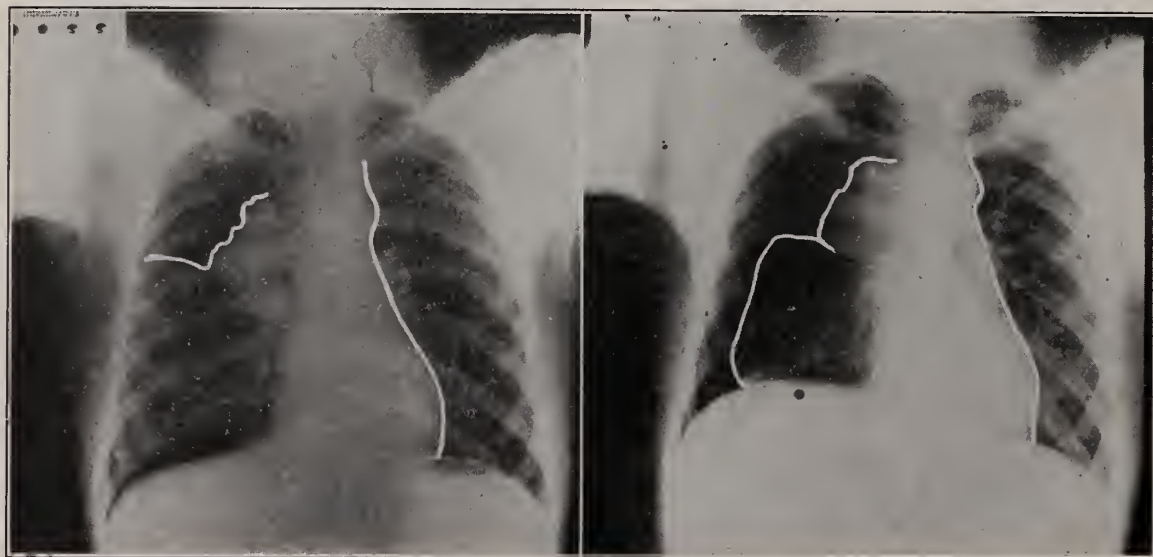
Roentgenograms of chest of W. A. on full inspiration. Before paralysis of the right diaphragm the corresponding lower lobe almost reaches the chest wall. After paralysis and without change in the intrapleural pressure this lobe is seen to be less expanded. A difference may also be noted in the upper collapsed lobe.
